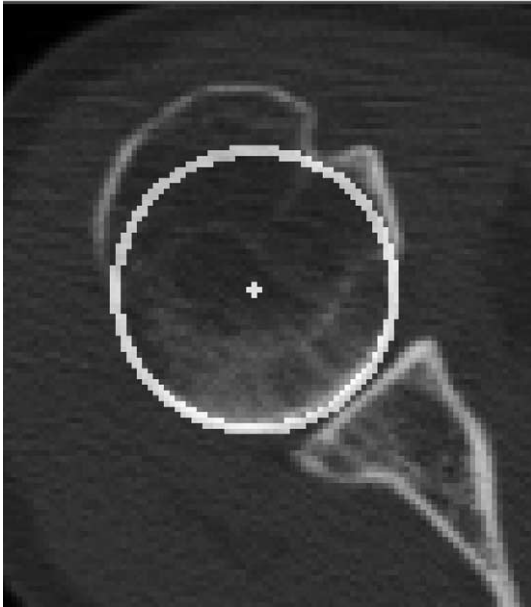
Detected humeral head centre and radius on CT image.
